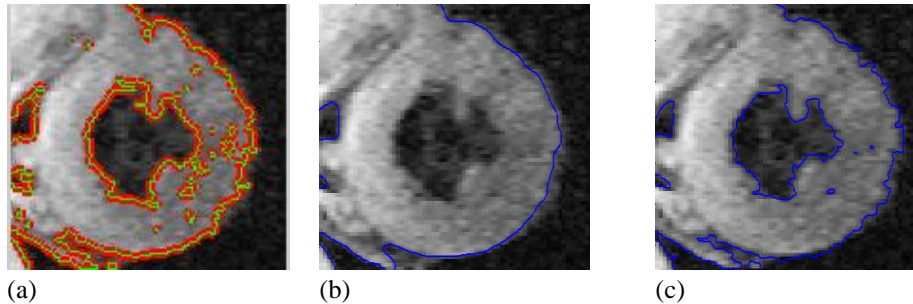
Experiment on the MRI image of a heart. The final results using the C-V, SGLACM, and proposed methods are shown in the first, second, and third columns for $\alpha=0.084$ and $\sigma = 1.0$, respectively.
